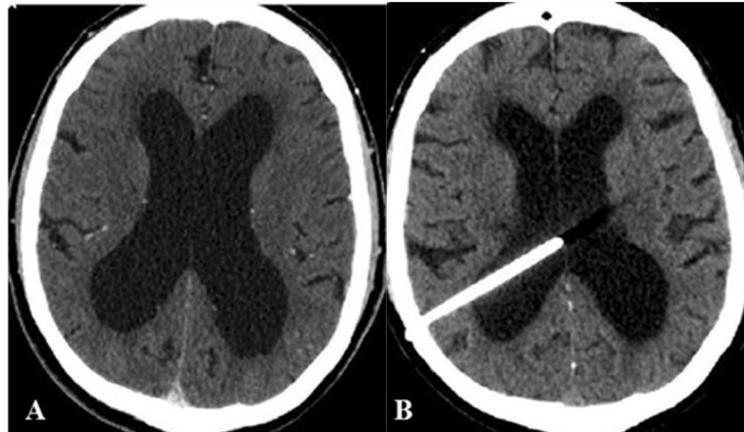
CT – hydrocephalus :
